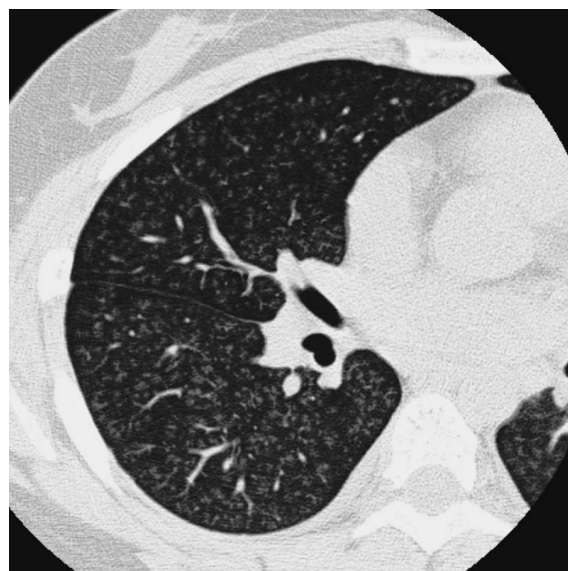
A computed tomography on admission. Chest CT showed diffuse centrilobular nodules.
